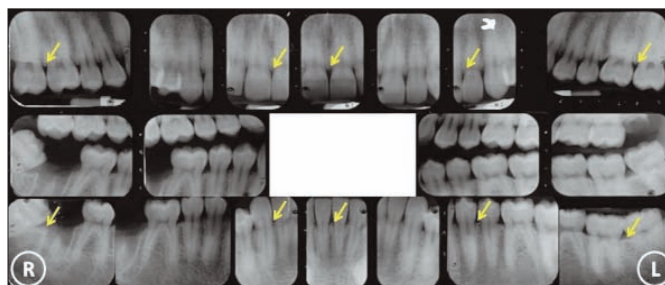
Intra-oral periapical and bitewing radiographs performed at the first visit showing alveolar bone at the cemento-enamel junction (yellow arrows) in both arches.
